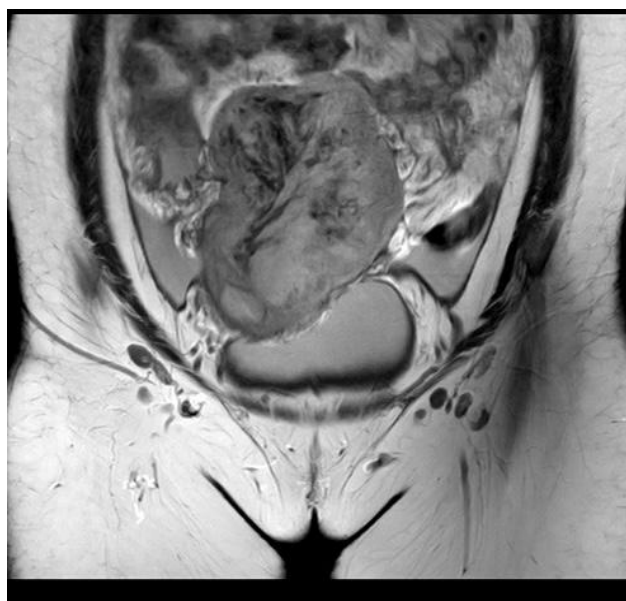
Ovarian leiomyoma MRI
